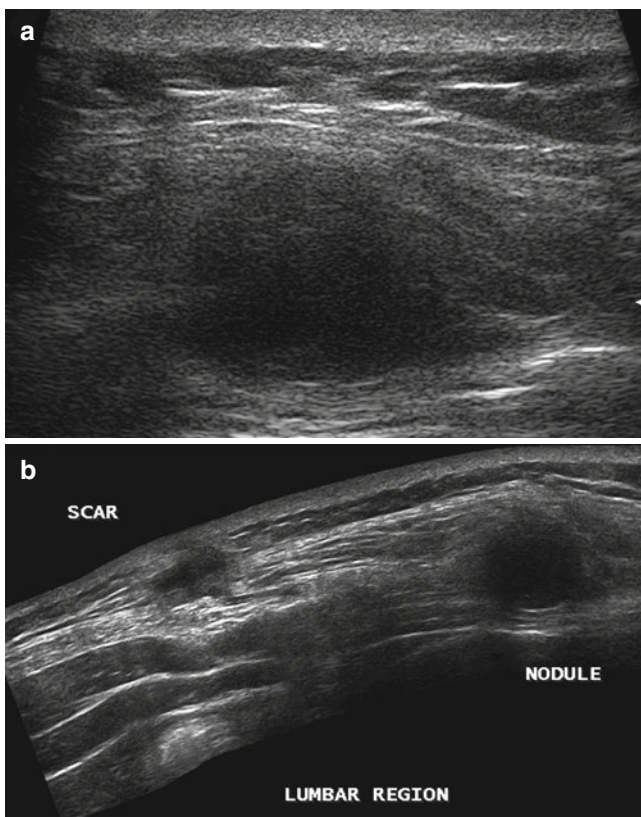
Lumbar recurrence. Ultrasound image revealing a deep nodule raising 5 cm far from the primary melanoma scar (a). Extended field of view reconstruction allowing for comprehensive depiction of the anatomic relationship between the scar and the new nodule (b)
